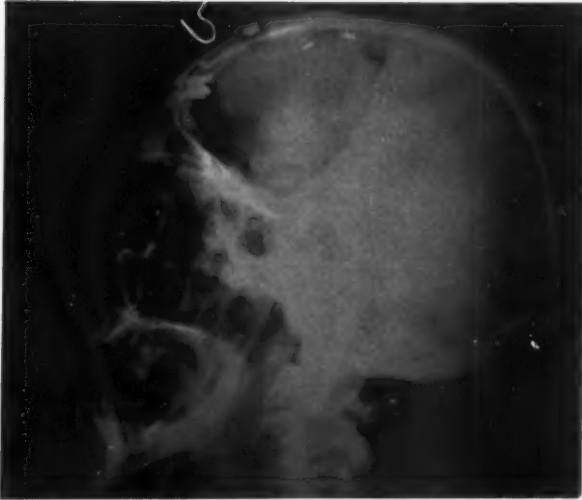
Case 9. Lateral x-ray after cranioplasty and removal of osteoma by osteoplastic approach.
